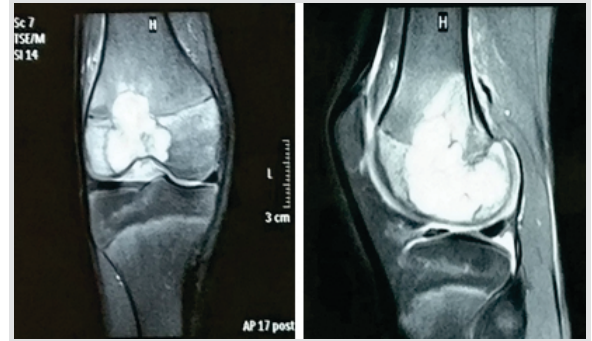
(a and b) Magnetic resonance imaging showing hyperintense lesion over distal femoral epiphysis extending into physis and metaphysis.
